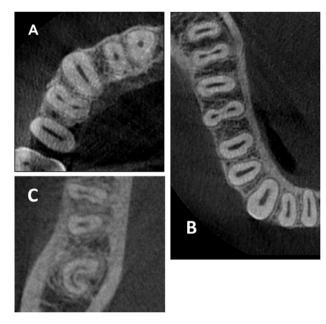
Flat-oval and C-shaped canals. CBCT axial view of (A) maxilla and (B) mandible reveal the flatness of root canals. Since the flatness is in a plane parallel to the X-ray beam of conventional intraoral radiographs, it is unlikely to be seen in periapical radiographs. Adapted from Metzger et al. (75). (C) CBCT axial view of a C-shaped canal, an extreme case of a flat-oval canal. Courtesy of Dr. M. Haapasalo, Vancouver, Canada.
